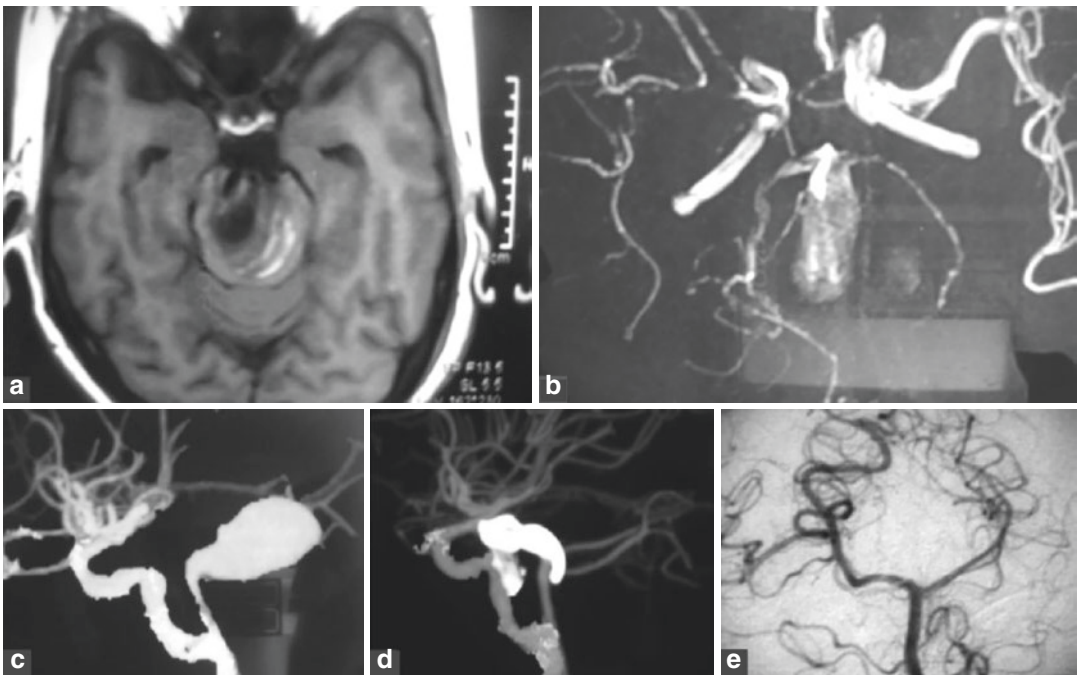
(a–c) MRI brain and MRA demonstrating giant heavily thrombosed basilar top aneurysm. (d, e) Postoperative CTA and DSA showing complete occlusion of the aneurysm and preservation of all vessels
